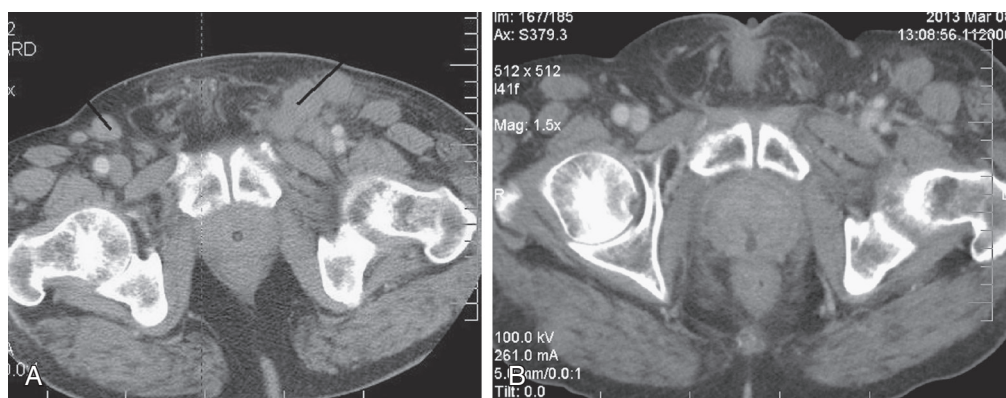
Locoregionally advanced penile cancer treated with EBRT and weekly cisplatin. A, diagnostic CT. B, Follow-up scan 2.5 years later. CT, Computed tomography.
